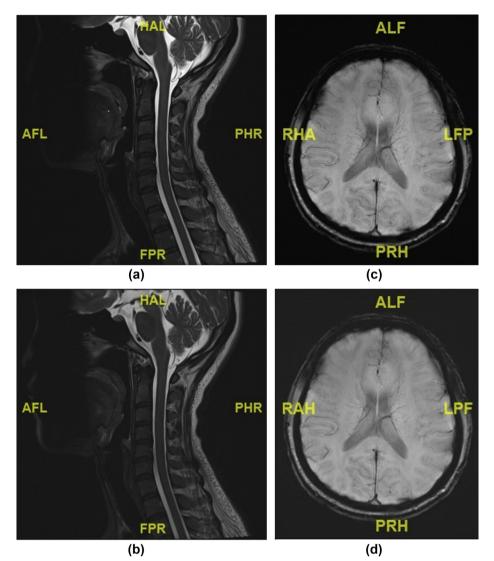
Representative 3-T MRI examination images of a healthy participant with and without the use of SIR HELMET. (a) Sagittal cervical spine image acquired in T2-weighted MRI using turbo spin-echo sequence utilising a head coil without SIR HELMET and (b) the equivalent image obtained with the presence of SIR HELMET. (c) Axial image of the brain acquired in susceptibility-weighted imaging utilising a head coil without SIR HELMET and (d) the equivalent image obtained with the presence of SIR HELMET.
